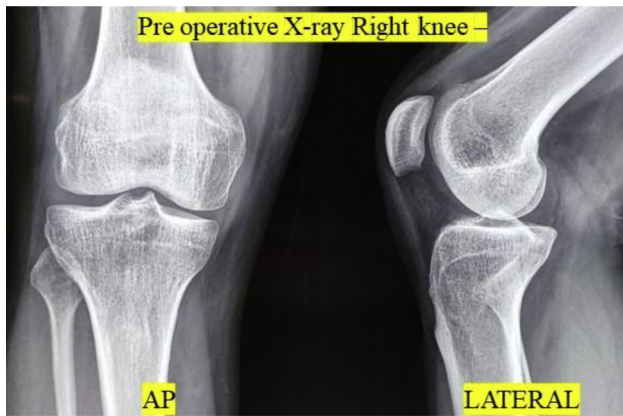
Preoperative radiographs of right knee: anteroposterior (AP) and lateral views.
